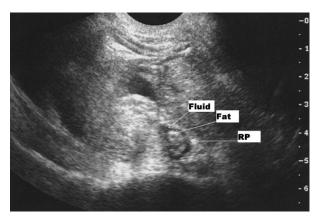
Transvaginal ultrasonography of the right ovary with the classic dermoid plug or Rokitansky protuberance (RP). The arrow demonstrates this classic ecogenic mass, representative of the fat/fluid interface within the dermoid cyst.
